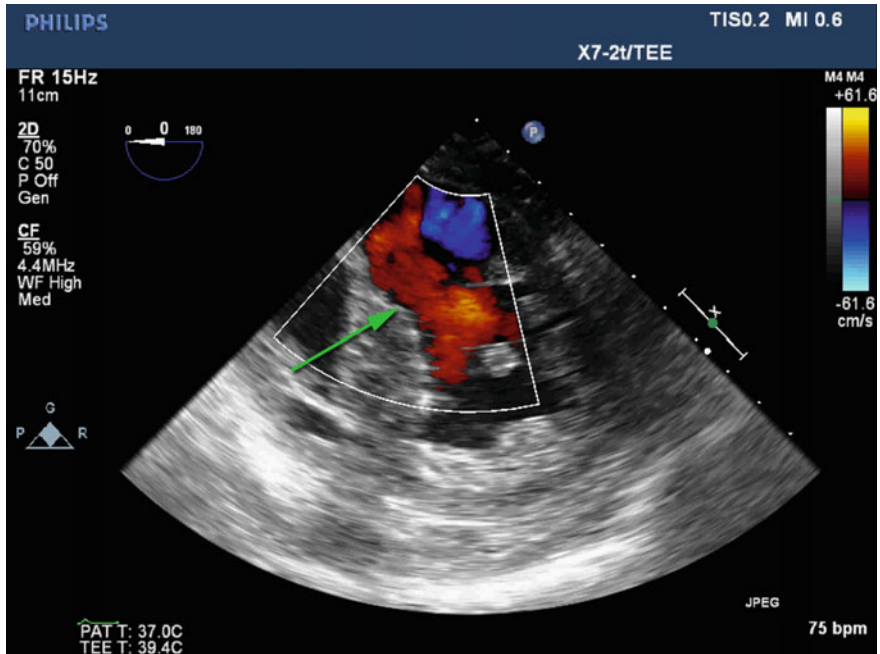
Transgastric midpapillary short axis view with color flow Doppler in a patient status post inferior myocardial infarction and inferior wall rupture (*green arrow*). Note the contained rupture with flow exiting the ventricular cavity
